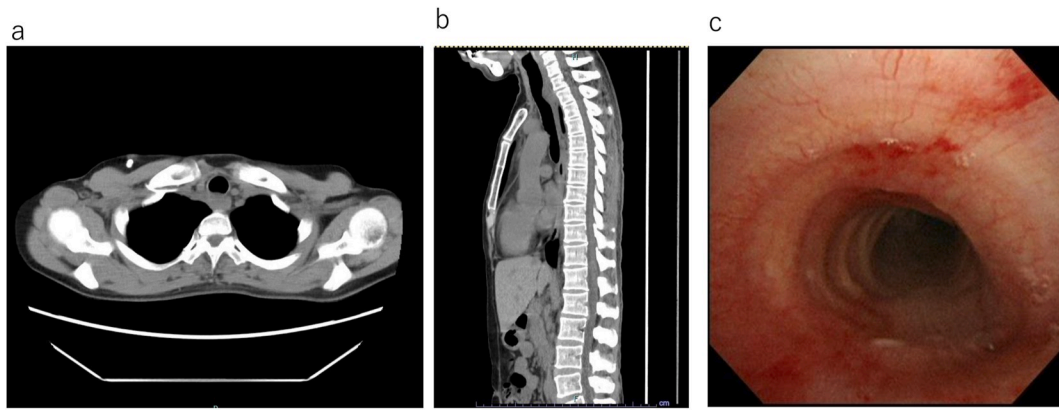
Computed tomography (CT) and endoscopic images obtained 2 months after the initial bronchial intervention. a. Horizontal section view of chest CT image. b. Sagittal section view. CT revealed that most of the tumor had been removed. c. Endoscopic view. The tracheal lumen was re-established via bronchial intervention.
